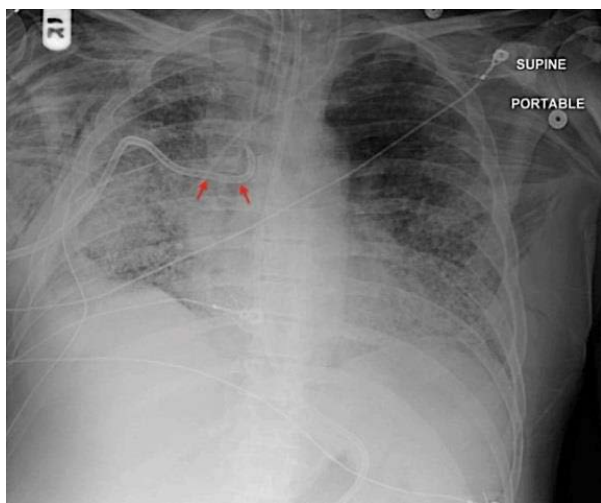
Chest X-ray showing pigtail in the right mainstem bronchus - with arrows.
